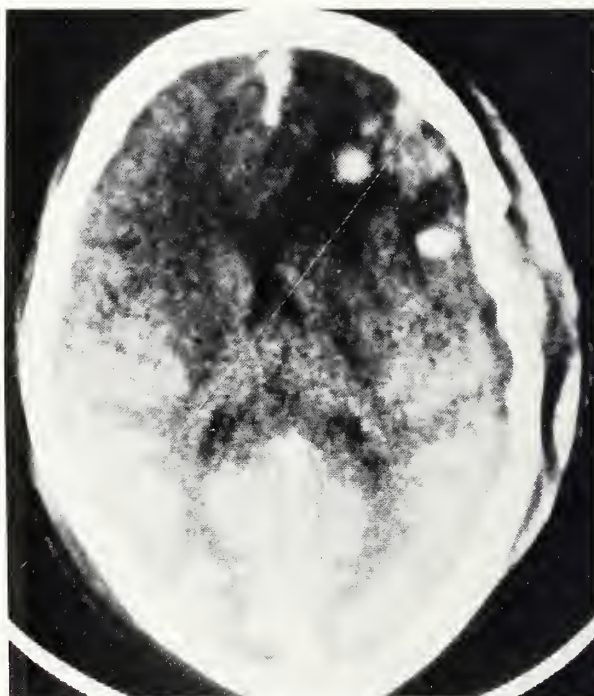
This CT scan shows right frontal contusion with only slight shift of ventricular system, indicating patient can be managed medically.
